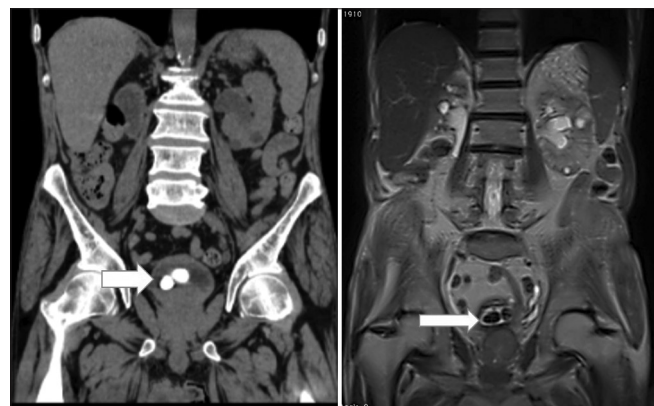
Coronal multiplanar reconstructions noncontrast computed tomography image (left) shows two hyperdense vesical calculus (arrow) while corresponding coronal T2-weighted magnetic resonance image (right) shows two hypointense filling defects (arrow)
